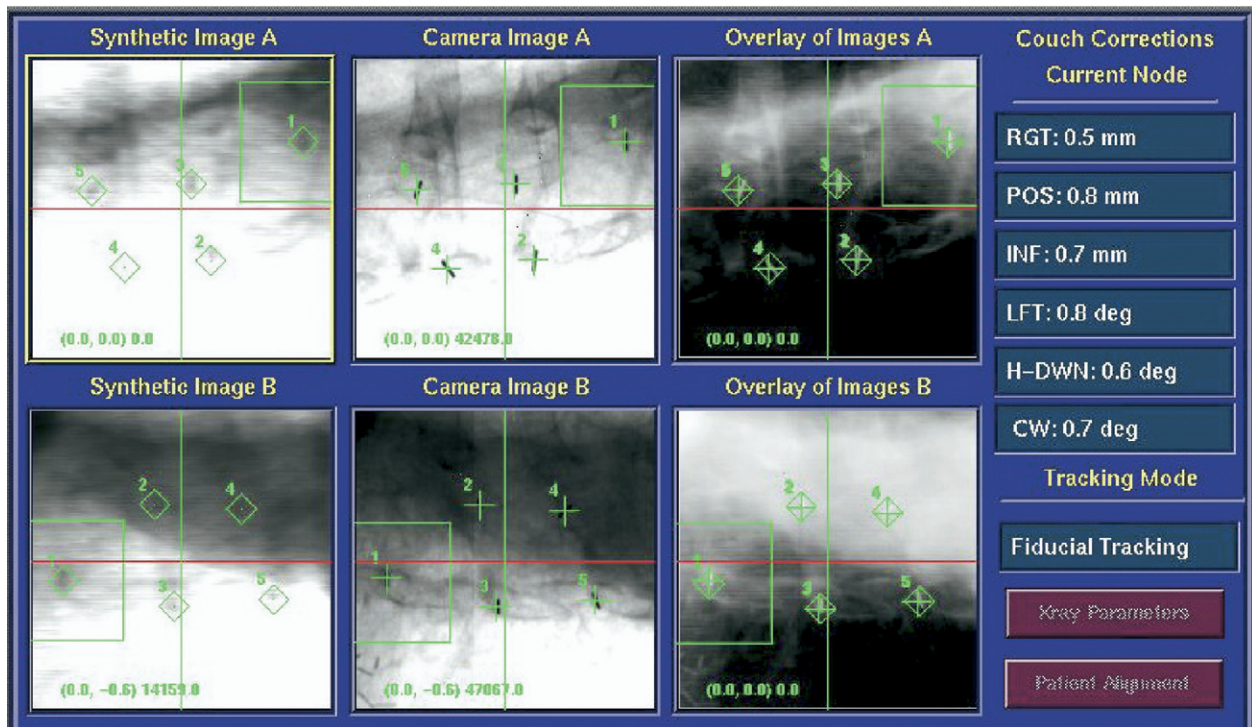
Repositioning of the region of interest (ROI) on live radiographs to extract fiducial markers.
